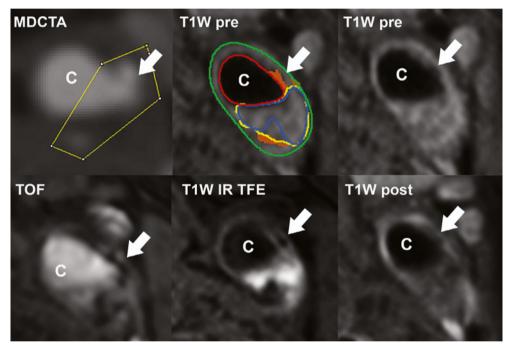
Example of how the use of a 600 HU threshold on MDCTA have led to underestimation of calcifications on MDCTA compared to MRI. Corresponding MDCTA and MR images of a patient in which the mismatch between MDCTA and MRI (MDCTA calcifications absent; MRI calcifications present) can be explained by the use of the 600 HU threshold on MDCTA: large calcification (arrow) is missed on MDCTA. C common carotid artery; arrow calcification.
